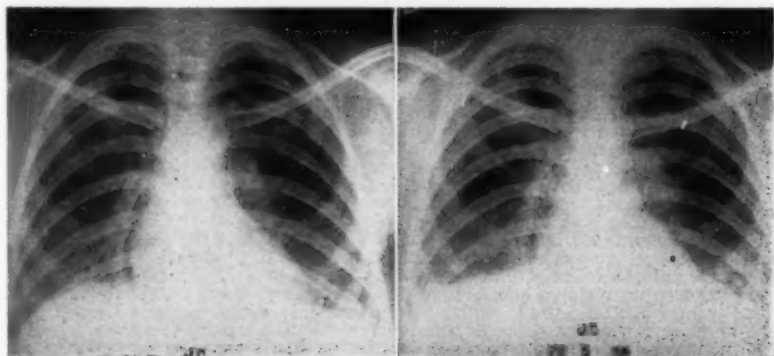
(Case 3): J. C., Chest roentgenogram, March 17, 1958 showing very fine but diffuse and extensive miliary process.
